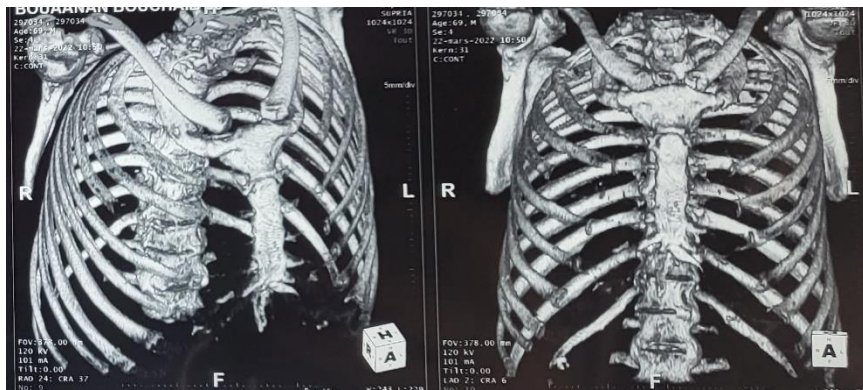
MIP 3d reconstruction CT scan displaying lysis of the anterior arch of the 4th rib
